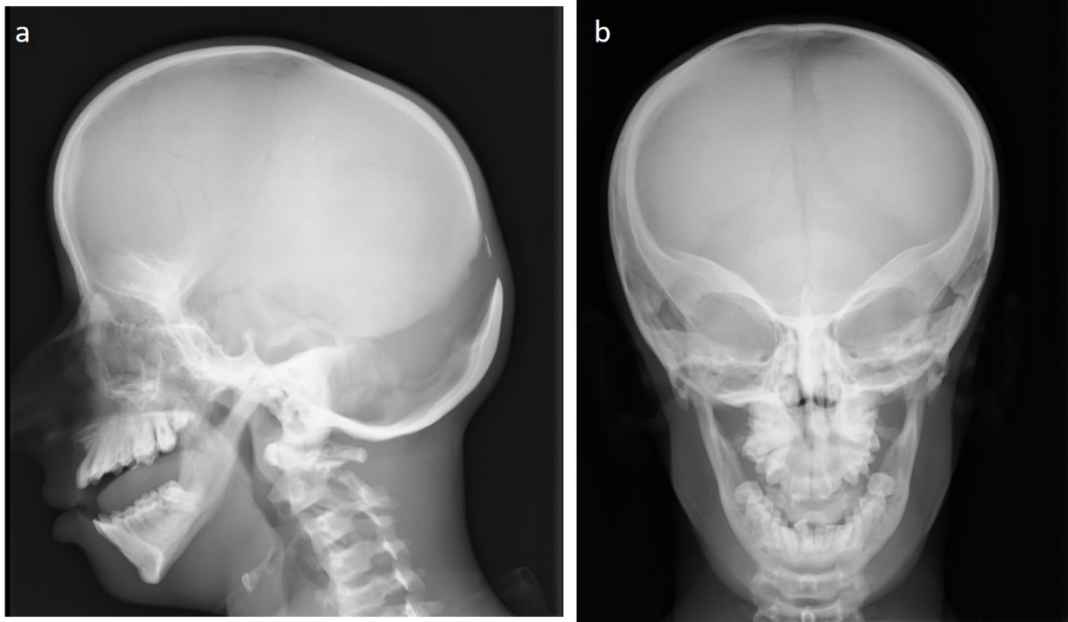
Skull X-rays: a) Anteroposterior view; b) Lateral view.
